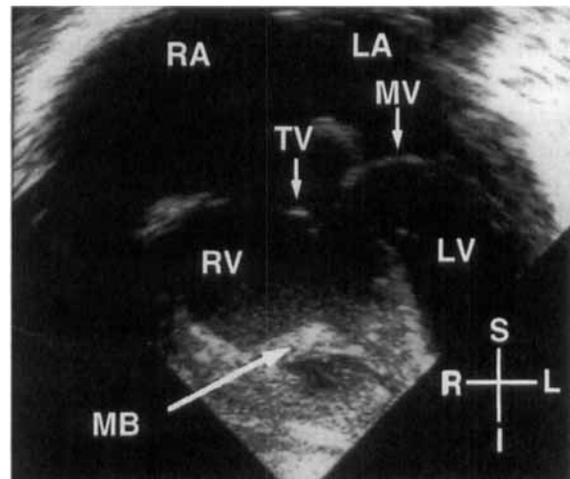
Apical four-chamber cross section recorded from a newborn with right heart failure secondary to a hepatic arteriovenous malformation. The right ventricle (RV) is dilated and hypertrophied and compresses the left ventricle (LV). LA = left atrium; MB = moderate band; MV = mitral valve; RA = right atrium; TV = tricuspid valve. Compass: I = inferior; L = left; R = right; S = superior.
